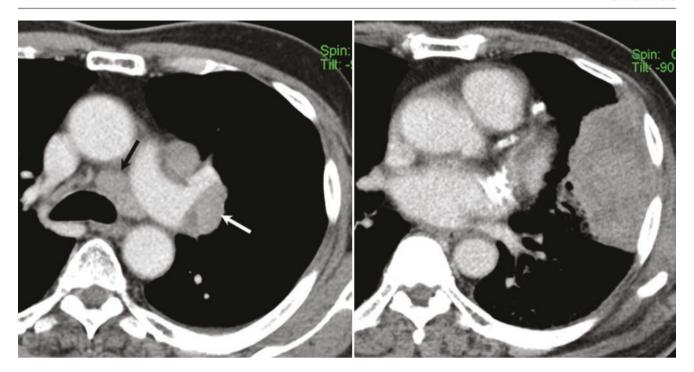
A 69-year-old man with small cell lung cancer. Contrast-enhanced axial CT images show enlarged mediastinal (black arrow) and left hilar lymphadenopathy (white arrow) associated with left upper lobe lung mass
